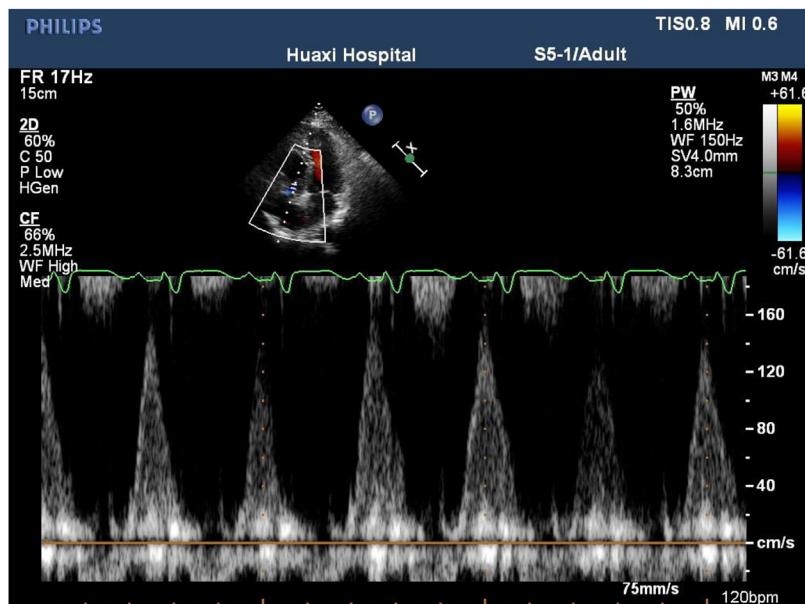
Increased Doppler gradient across the thrombosed tricuspid prosthesis.
